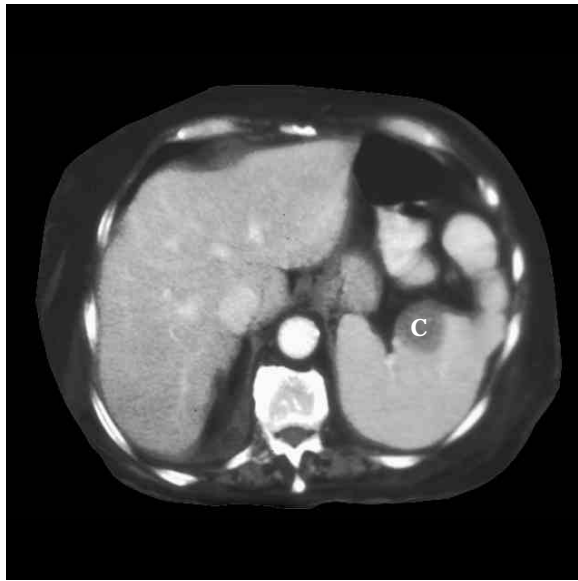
SPLENIC MASS CT image. CT scan of the spleen is considered the best tool for diagnosing splenic disorders such as tumors, abscesses, or cysts (C).
